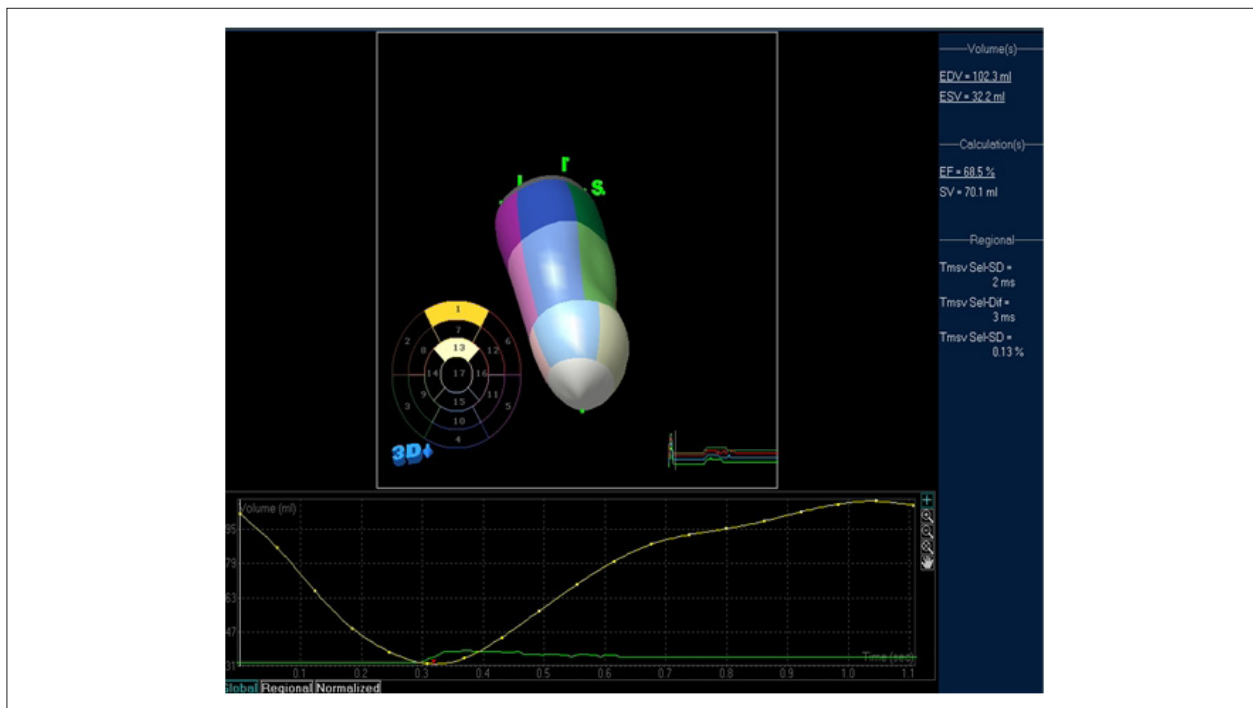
Measurement of the ventricular volumes and of the ejection fraction of the left ventricle measured with the use of three-dimensional trans thoracic echocardiography; EDV (end diastolic volume): 102.3 mL; ESV (end systolic volume): 32.2 mL; EF (ejection fraction): 68.5%; SV (ejected systolic volume): 70.1 mL.
